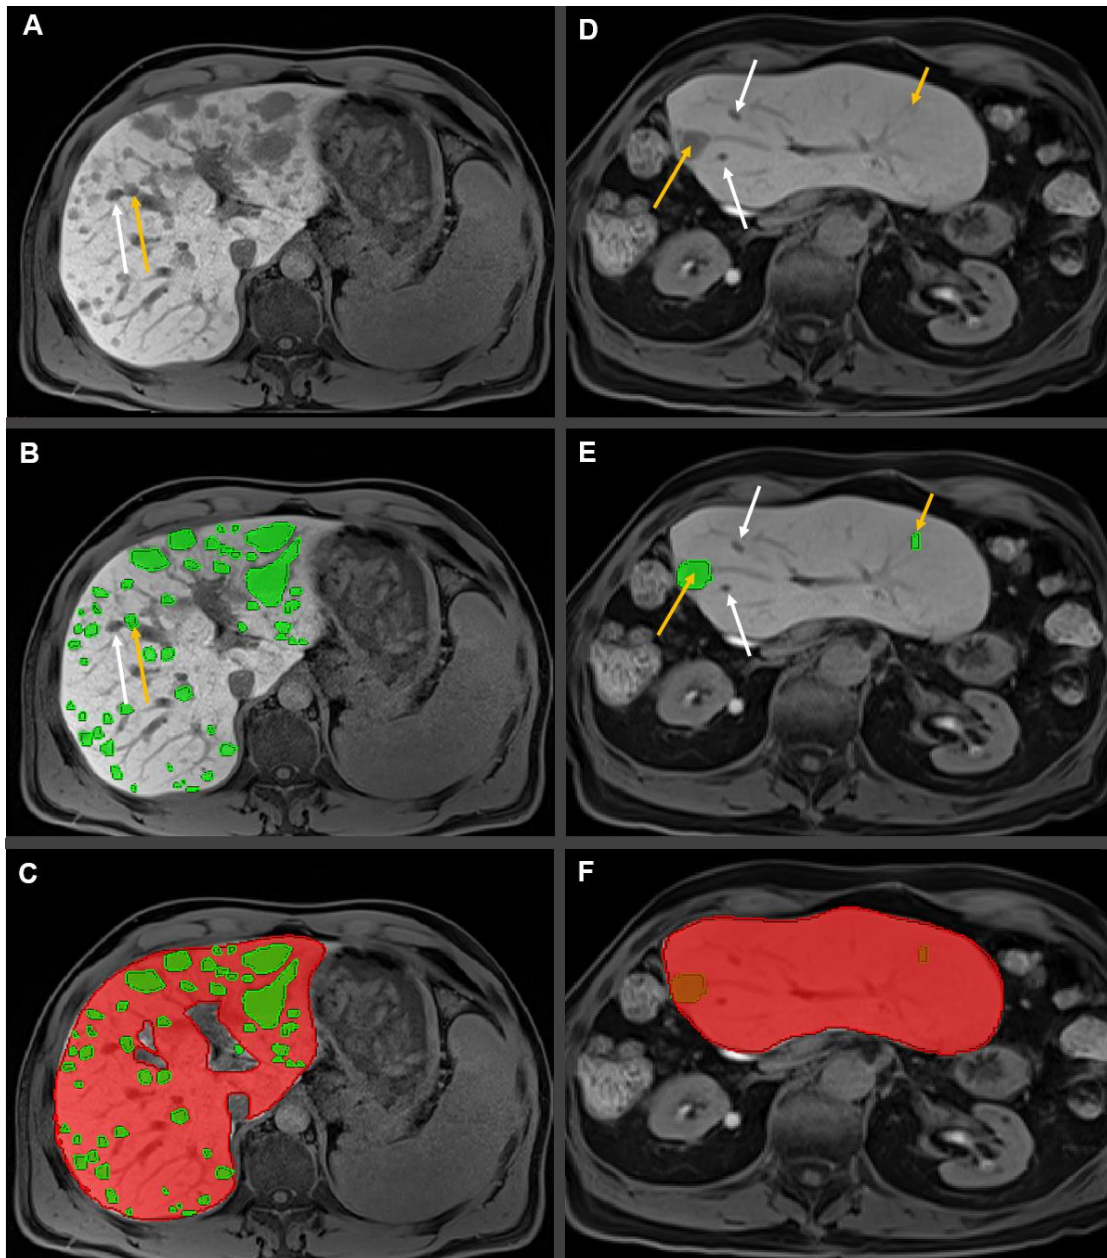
Examples of manual segmentation of NELMs (green areas in B, E) and the liver (red areas in C, F) on different slices of the HBP sequence on Gd-EOB-MRI (A, D). (A, B, C) diffuse pattern NELMs case; (D, E, F) post right hemihepatectomy case. Yellow arrows indicate the NELMs, whereas, white arrows indicate hepatic vessels (A, B, D, E). The HBP sequences were acquired 20 min after manual bolus injection of Gd-EOB-DTPA.
